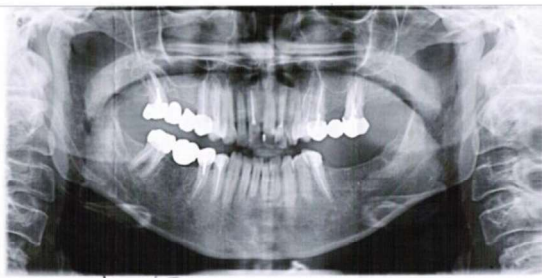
panoramic x-ray before surgery
